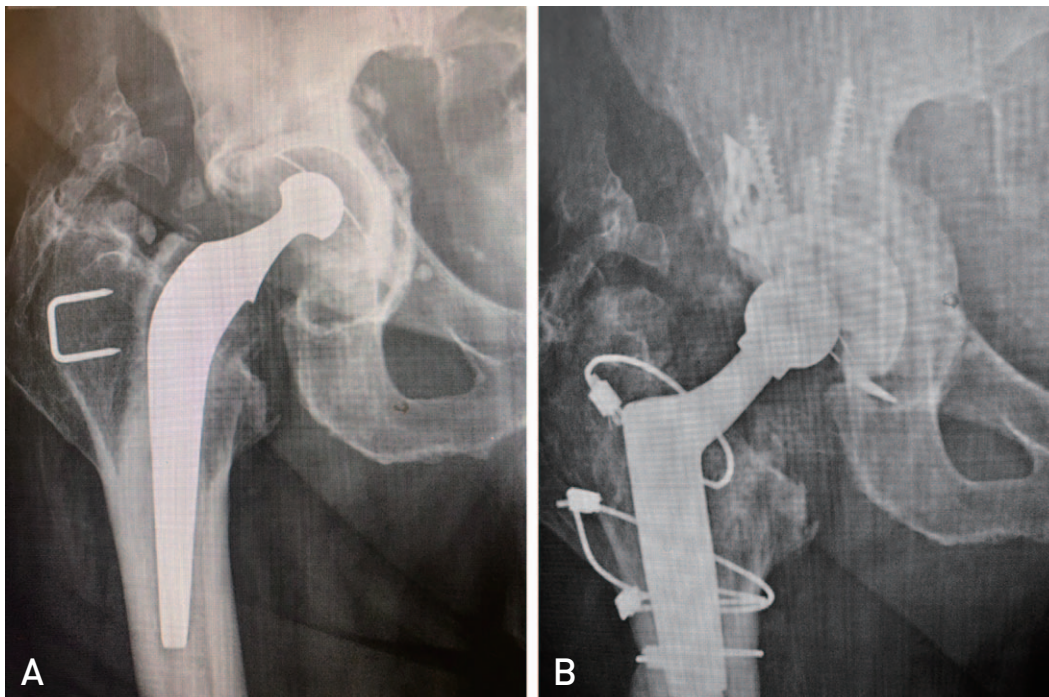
Preoperative radiograph 2009 (A) and 10-year postoperative (B) radiographs 2019 of an 83-year-old patient undergoing revision of cemented total hip replacement.
